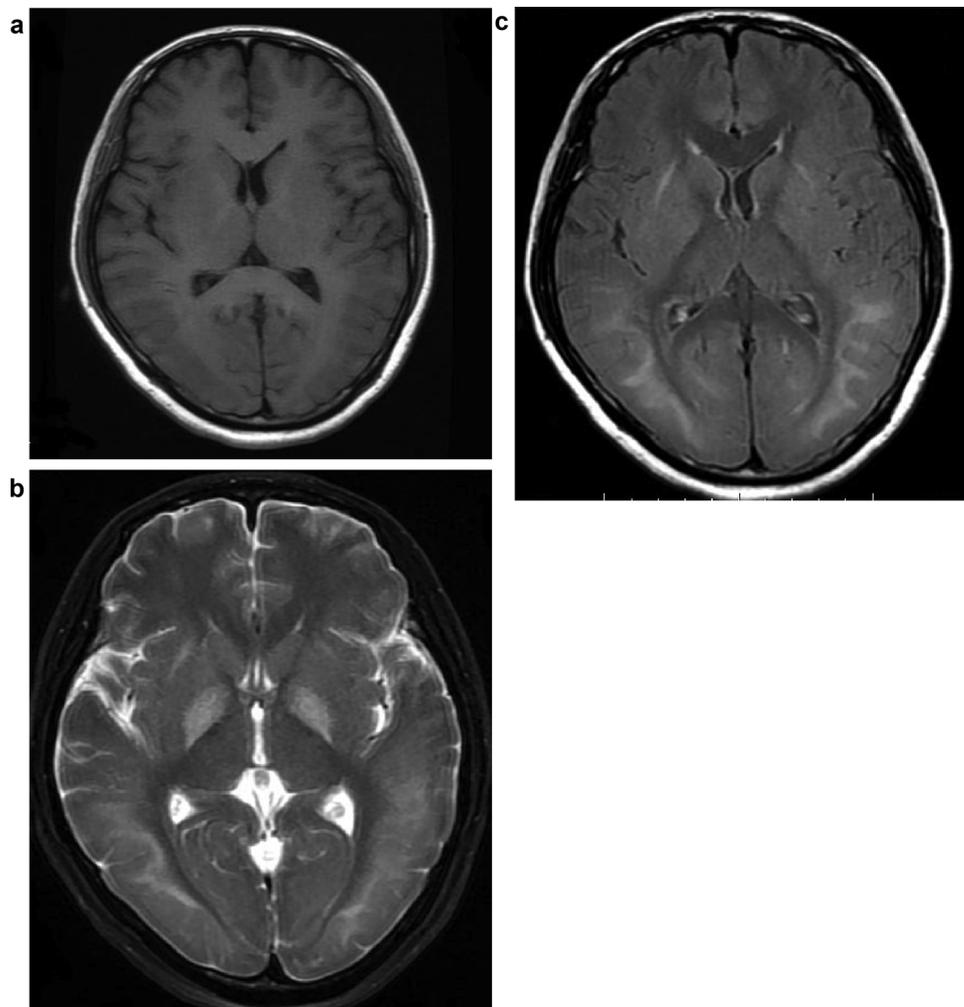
A 39-year-old woman with toxic encephalopathy induced by 1, 2-DCE. T1-weighted image (Aa) showed swelling gyri and shallow sulci in bilateral occipital lobes. T2-weighted image (Ab) showed bilaterally symmetrical hyperintensities in the globus pallidus and the posterior deep white matter. Fluid-attenuated inversion recovery (FLAIR) image (Ac) showed high signal intensity lesions in the same area. No abnormal enhancement of the lesions has been found on the enhanced T1-weighted MR images (Ad).
